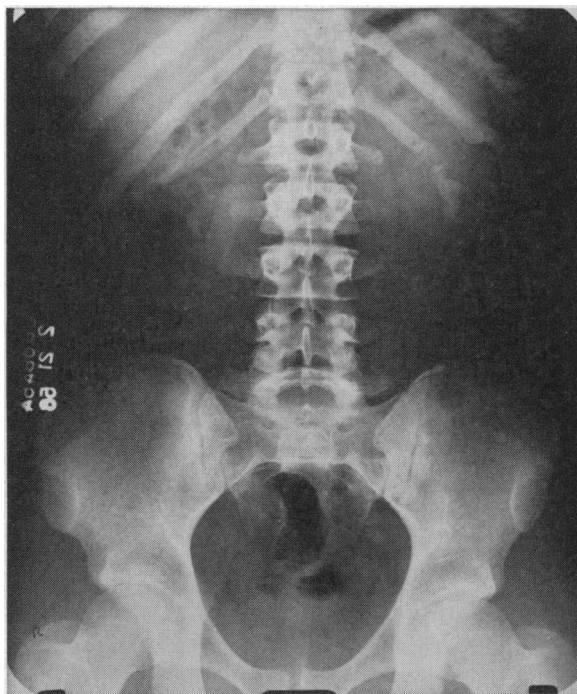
(Case 2).—Kidney-ureter-bladder x-ray film. The calculus filling the lower calyces and infundibulum is clearly shown.
